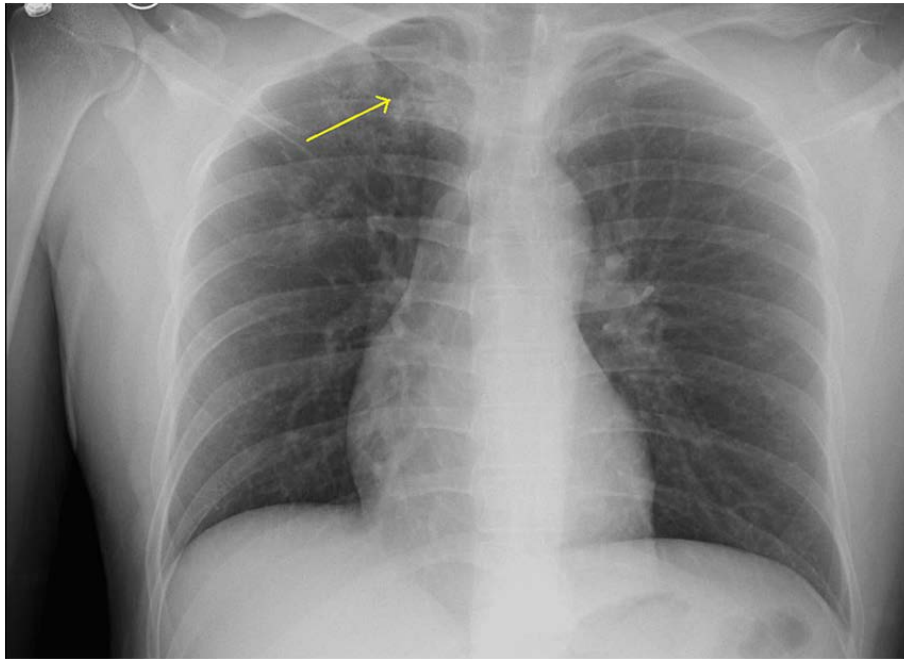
CXR: Patchy opacity of the right apical lung. Further examination with CT imaging warranted. CXR: Chest X-Ray; CT: Computed Tomography
